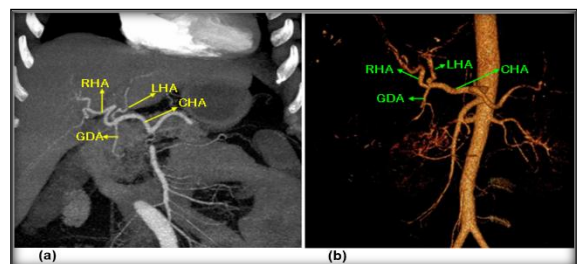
Coronal MIP image (a) and 3D reconstructed image (b) of CT angiographic data demonstrating Trifurcation of the CHA into the RHA, LHA and GDA
